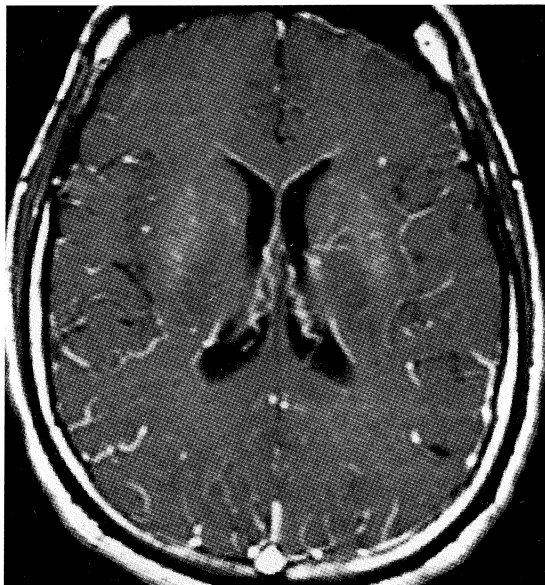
Post-gadolinium T1-weighted axial image showing widespread and florid leptomeningeal enhancement.
